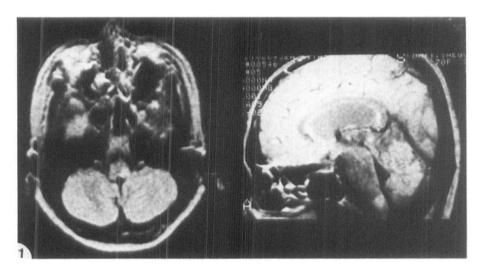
The magnetic resonance imaging (MRI) of case I shows a high intensity area in the left lateral dorsal medulla.
